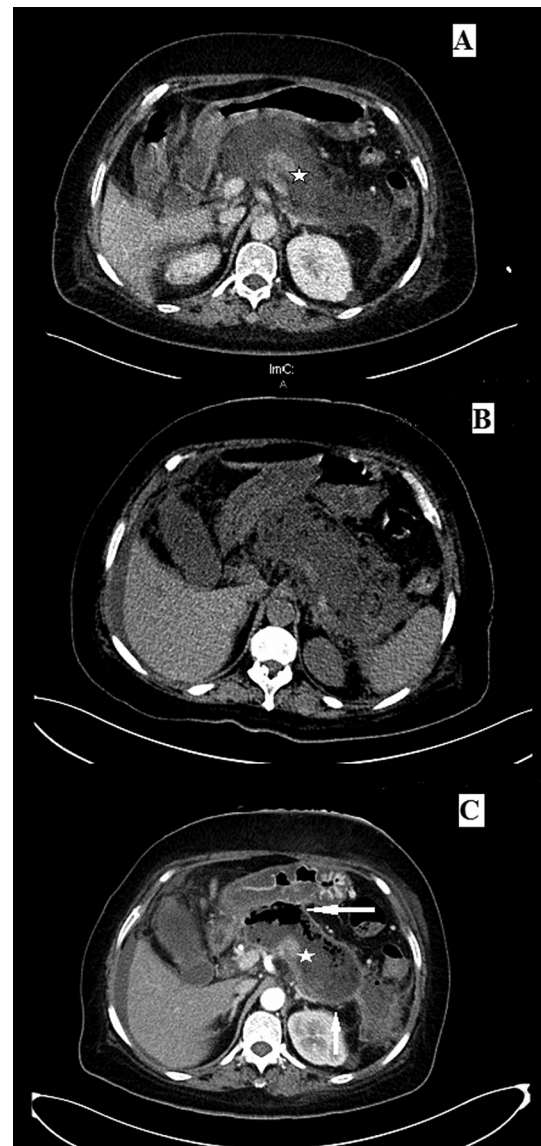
(A) CECT scan of a 51 year-old female patient with acute pancreatitis 9 days after onset of symptoms. Normal enhancement of a part of the body of the pancreas (white asterisks) existed. (B) In unenhanced CT performed 23 days after onset, no gas bubbles were found. (C) About 32 days after onset, the patient started to have persistent fever, and a CECT scan was performed 3 days later. The scan revealed a walled-off necrotic collection complicated by infection (white asterisks denote normal enhancing pancreas; the white arrow above points at the gas bubbles in the necrotic collection, and the white arrow below points at the wall of the necrotic collection).
